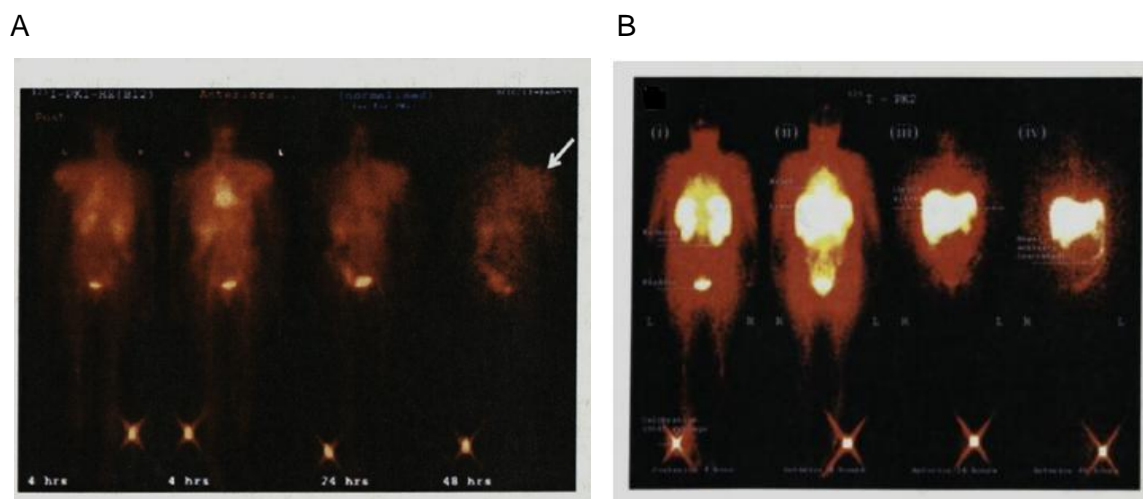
A, Gamma scintigraphic imaging of  $^{123}\text{I}$ -labeled PK1 in a breast cancer patient with a metastatic lesion in the left shoulder region as indicated by the arrow; B, gamma scintigraphic imaging of  $^{123}\text{I}$ -labeled PK2 in four hepatocarcinoma patients. Adapted from Ref [97].
